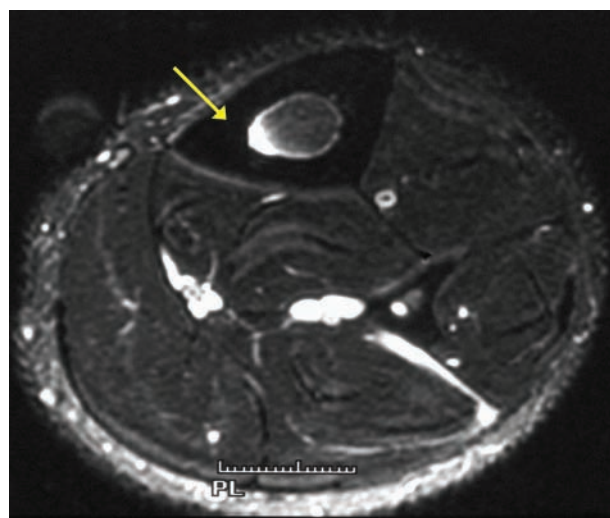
Grade 2 bone stress injury of the tibia on magnetic resonance imaging. Arrow points to moderate marrow edema on the T2-weighted image. Grade 2 includes moderate marrow or periosteal edema on the T2-weighted image (but not T1).
